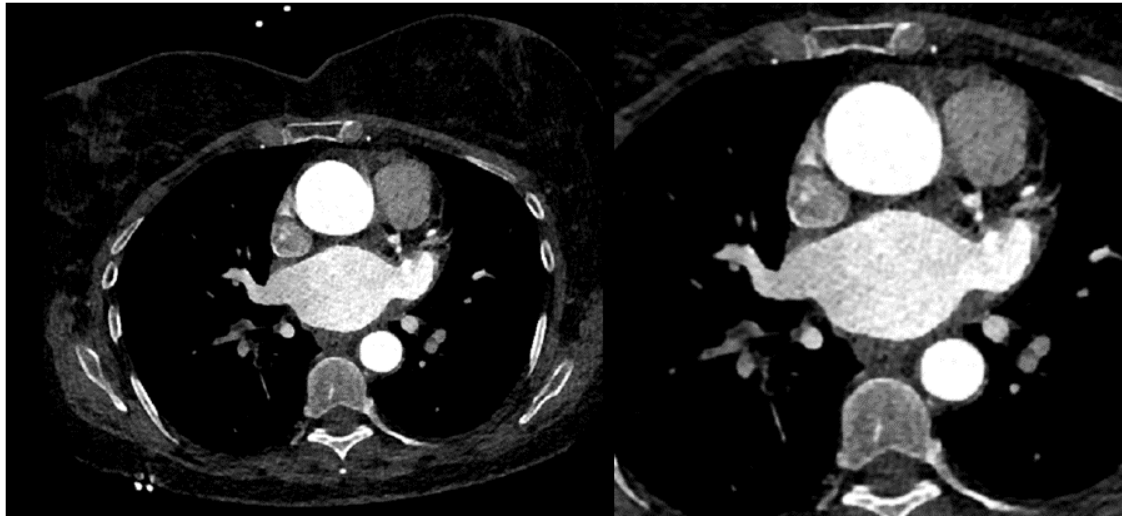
CT scan with contrast liquid resized from 512x512 pixels to 255x255, to center the LA.
